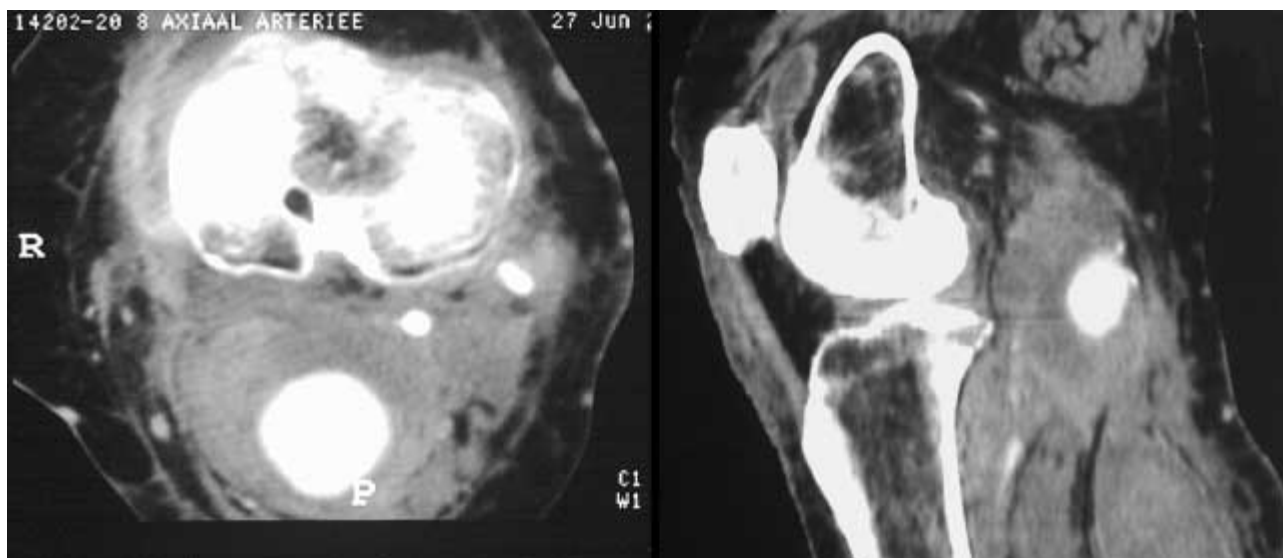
Axial and sagittal CT-angiography of the pseudoaneurysm complicating partial arthroscopic medial meniscectomy. The popliteal artery, geniculate branches and the pseudoaneurysm are well visible and are not connected.
